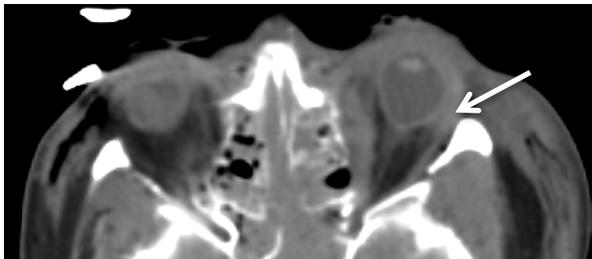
Elongation of left optic nerve (49-year-old male with elevated IOP). CT, transverse section: Elliptical-shaped left globe (white arrow), the optic nerve presents elongated accompanied by diverse fractures of the osseous orbit.
